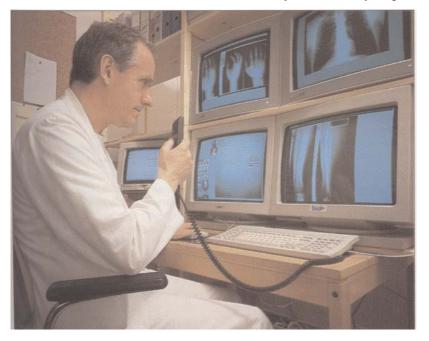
Radiologist making diagnosis from digitised X-rays, viewed on a Mira installation with four screens. All the equipment is off-the shelf. The two lower screens are connected directly to the computer, the two upper screens are networked X-terminals
